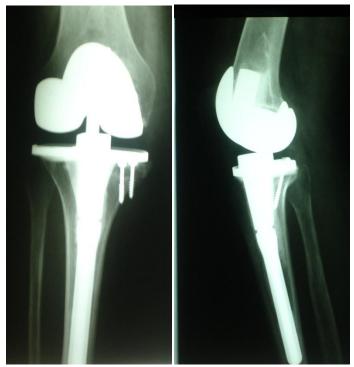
9 months follow up x-ray with excellent result and complete bone graft incorporation
